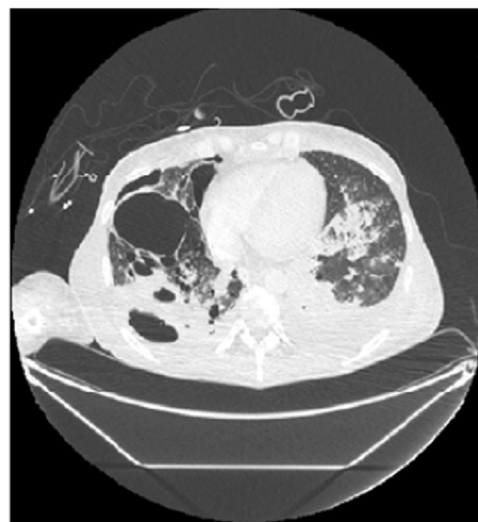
Chest CT scan performed on Day-14.
